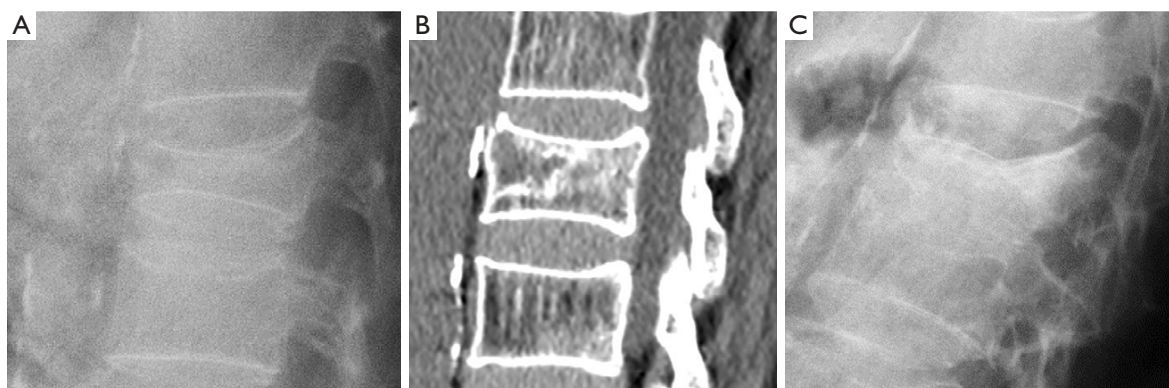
Intravertebral fracture instability. (A) Standing radiograph with marked local kyphosis that is reverted in supine CT (B). (C) Follow-up radiograph showing severe collapse of the vertebral body.
